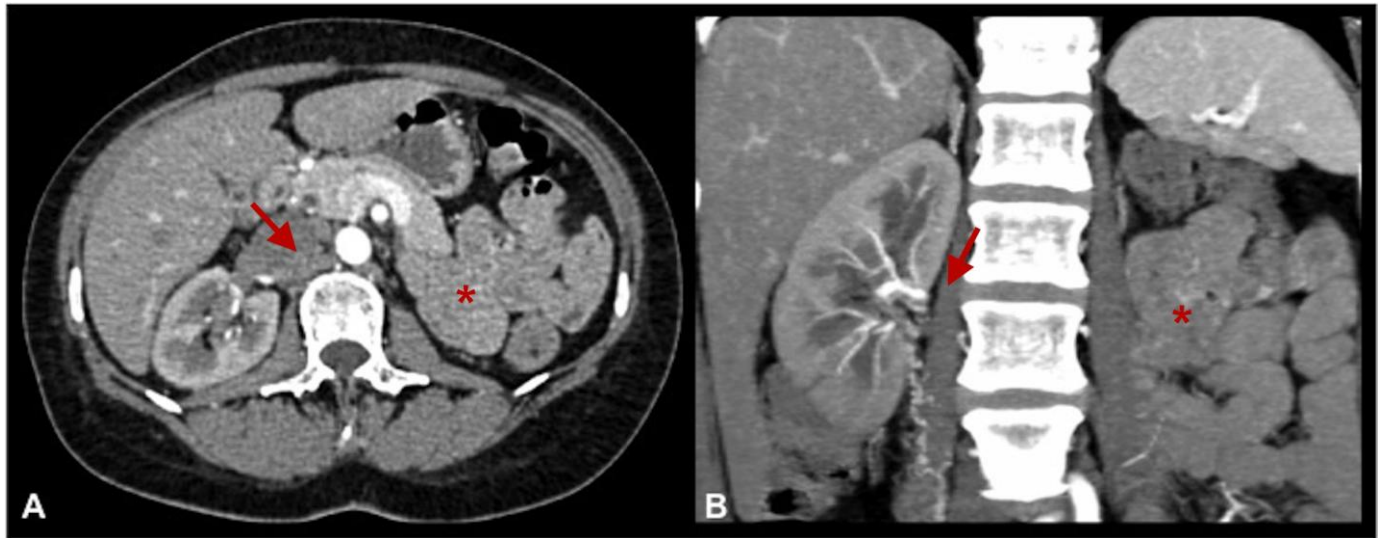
49-year-old female patient with diagnosis of FMD. CTA (arterial phase; 120 kV, 1247 mAs) after injection of 120ml Ultravist (Bayer HealthCare, Leverkusen): On axial (a) and coronal (b) reformations no right renal artery is seen in terms of total vessel occlusion (red arrows). Parenchymal contrast is reduced with proper differentiation of renal medulla and cortex. Status post nephrectomy on the left side (red asterisk).
